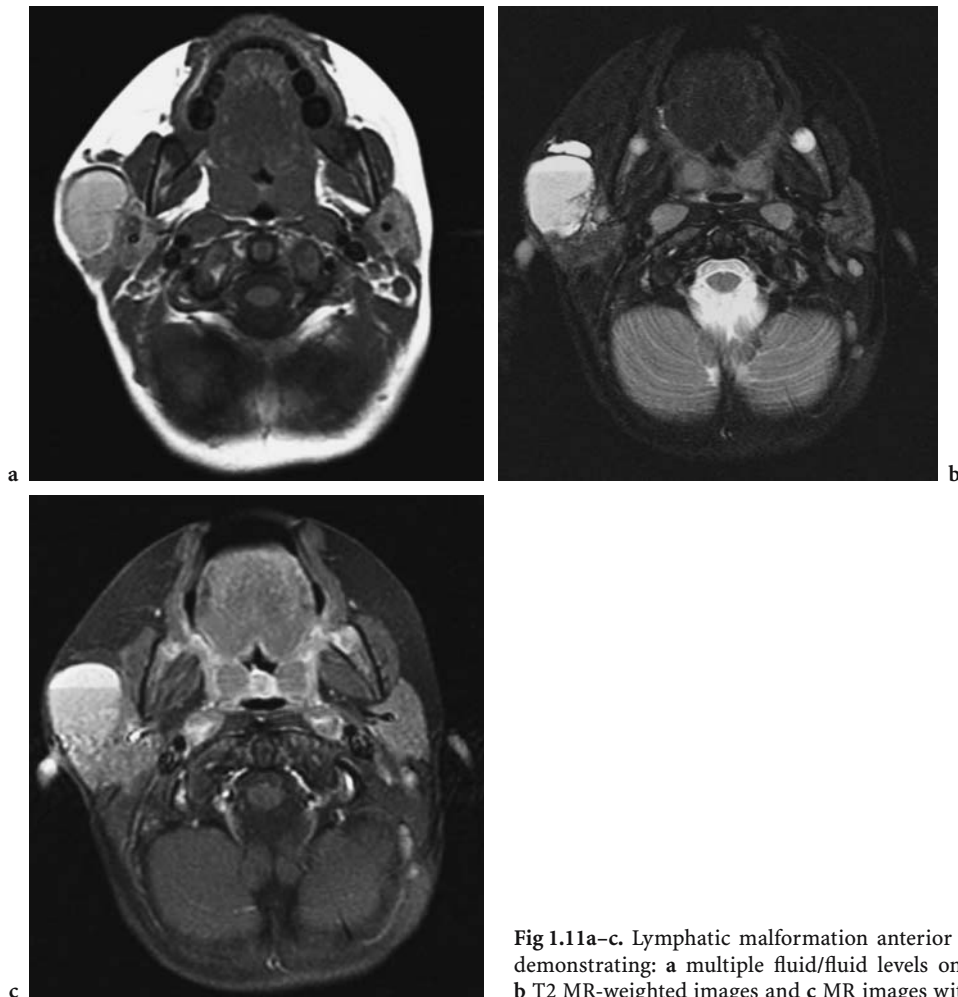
Lymphatic malformation anterior to the right parotid gland demonstrating: a multiple fluid/fluid levels on T1 MR-weighted images, b T2 MR-weighted images and c MR images with gadolinium
